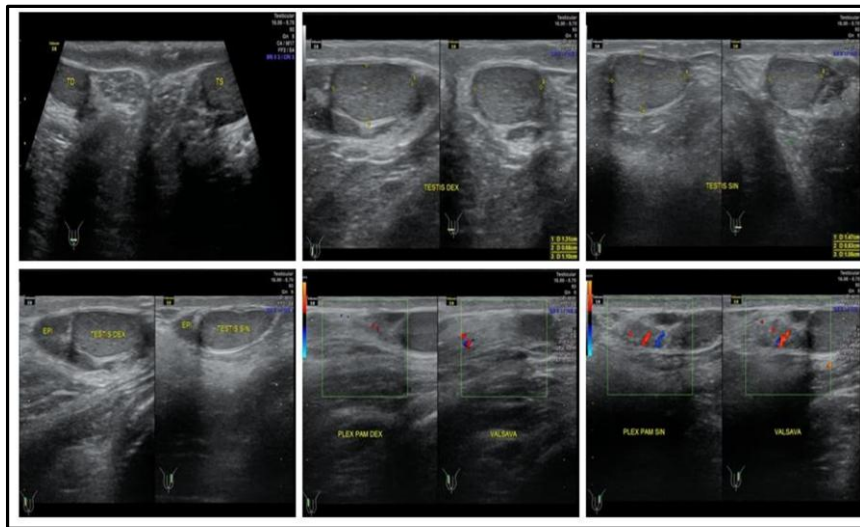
Ultrasound of the patient's testicles on June^{6th} 2023, Impression of bilateral testicular atrophy (right testis measuring 1.31 x 0.68 x 1.1 cm; left testis measuring 1.47 x 0.83 x 1.05 cm). No varicoceles were seen in the bilateral testicles.
